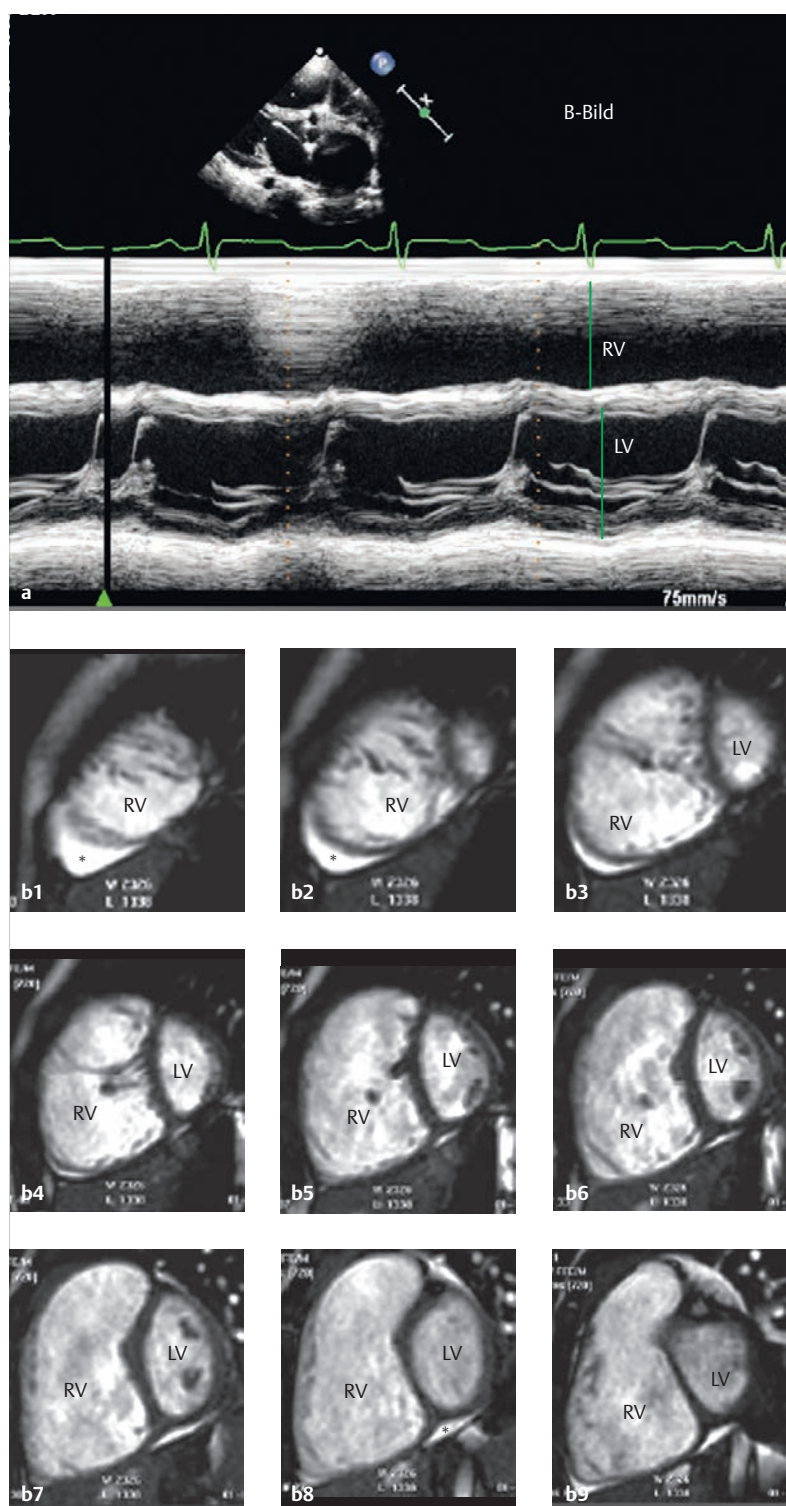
Right ventricular volume overload caused by an ASD. Right ventricular volume overload caused by an ASD is already visible adjacent to the transducer using a 2-D TTE along the parasternal long axis, even in a B-mode image (a). Precise quantification is possible during M-mode, based on the end diastolic and end systolic diameters of the right ventricle. The left ventricular parameters can also be communicated in this fashion. Due to the complex right ventricular geometry, MRI (b) using the slice summation method (Simpson's method) still offers significant advantages compared to echocardiography. The end diastolic short-axis slices via the complete right and left ventricle using cine MRI and SSFP sequences for the same patient depict the significantly dilated right ventricle due to pronounced volume overload through the resulting left-right shunt.
